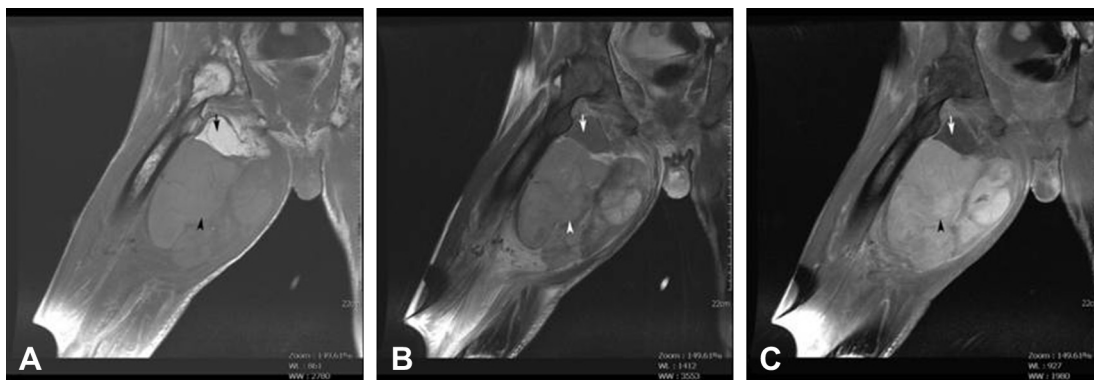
Magnetic resonance imaging findings. (A) Coronal T1 weighted imaging, (B) fat-suppressed T2 weighted imaging, and (C) fat-suppressed Gd-enhanced T1 weighted imaging revealed a large multi-lobulated soft tissue mass in the right upper thigh. The superior portion of the lesion indicated a signal intensity similar to that of fat tissue (arrows) without contrast enhancement. The inferior portion of the mass (arrowheads) manifested as an unspecified soft tissue mass with a low to intermittent T1 signal, a mild high T2 signal and a moderate degree of heterogeneous contrast enhancement. The tumor abutted on the medial surface of the right femur without focal bone destruction or intramedullary extension. The femoral neurovascular bundle was displaced laterally and anteriorly by the mass. The preoperative magnetic resonance imaging diagnosis was liposarcoma.
